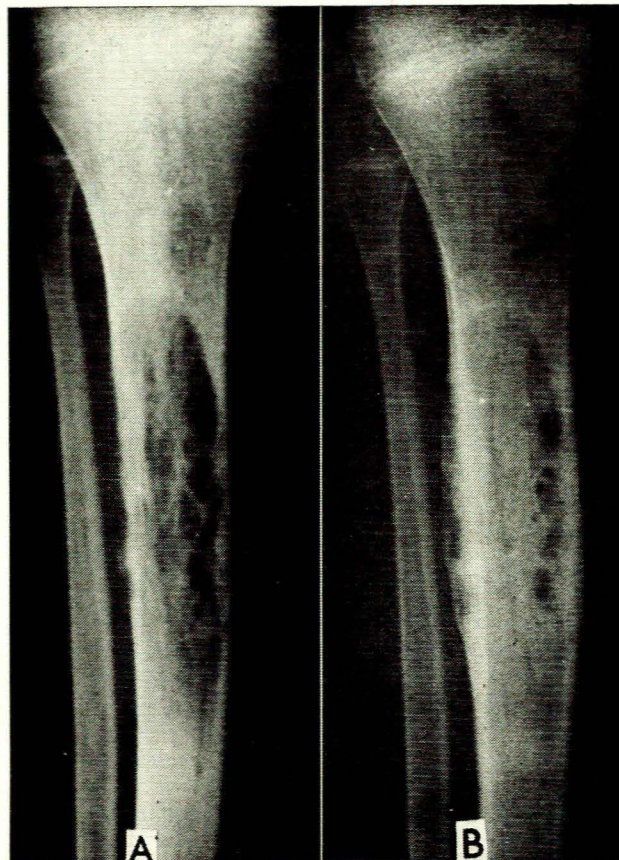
A — X-ray film of the right tibia showing the multicyclic lesion and cortical and periosteal erosion on the lateral aspect of the tibial shaft. B — X-ray film of the right tibia after radiotherapy and chemotherapy showing the healing and subperiosteal new bone formation covering the previously eroded areas.
